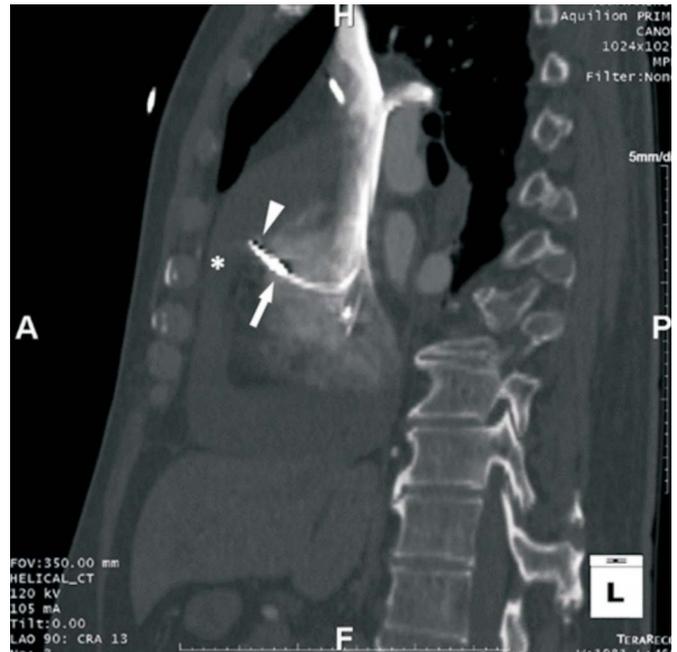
Reconstruction CT demonstrates massive pericardial effusion (*) with a water bottle sign and the tip of right atrial lead (arrow) outside RA wall (arrowhead).
